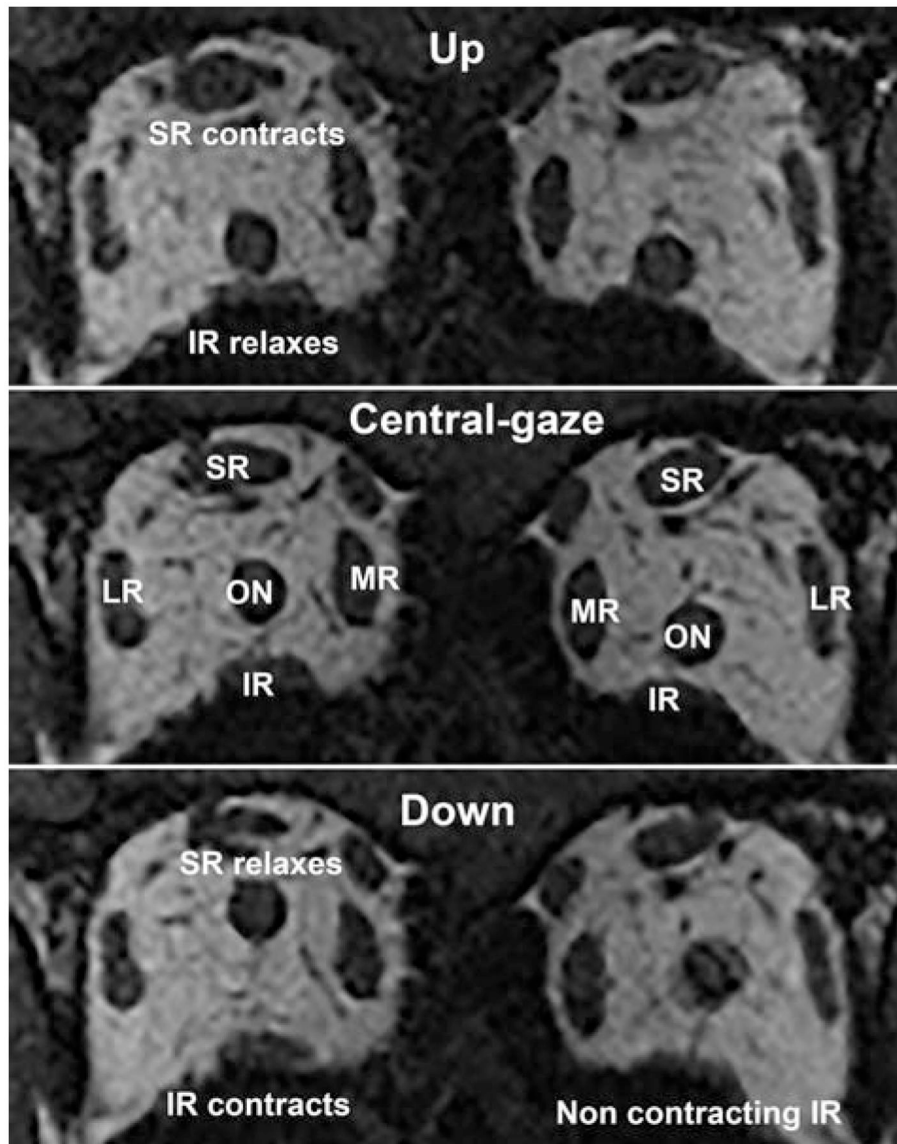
Case 5. Quasi-coronal T2 MRI of right (left column) and left (right column) orbits of case 1 in supraduction (top row), central gaze (middle row), and infraduction (bottom row) showing atrophy of the left IR that lacks contractile changes with attempted infraduction.
